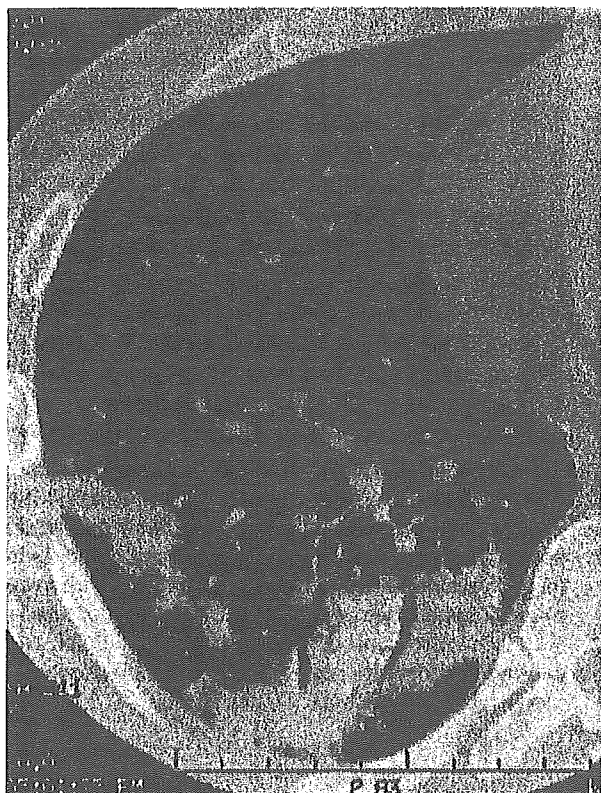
Chest CT scan of a symptomatic patient with pulmonary cryptococcosis who had no underlying disease. Note the patchy areas of air-space consolidation with air-bronchograms, and adjacent ground-glass opacities in the subpleural region in the right lower lobe.
